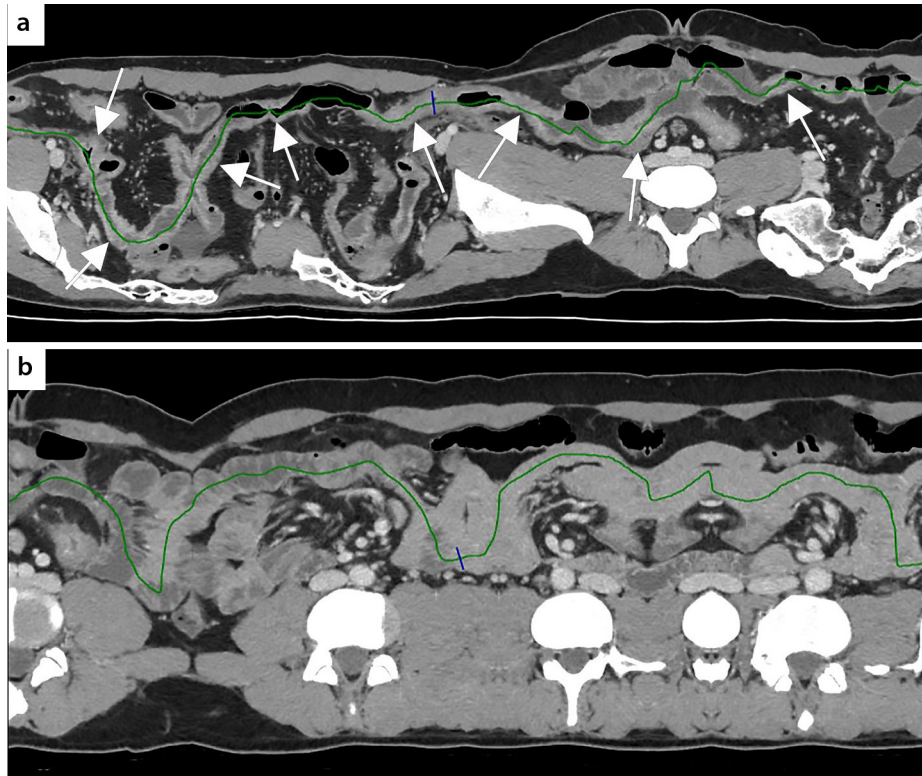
Computed tomography enterography reconstruction (a) reveals extensive alteration of the small loops, both the distal jejunum and ileum, including the last ileal loop and ileocecal valve, for at least 140 cm. The ileocecal valve is poorly identifiable. Immediately upstream, further ileal loops are observed with thickened walls (maximum thickness 10 mm) with an extension of approximately 30 cm and a lumen of reduced caliber (3 mm). The ileum upstream and distal jejunum have at least eight pathological tracts with thickened walls (maximum thickness 7 mm), with a longitudinal extension varying from 2 to 6 cm, and reduced caliber (residual lumen of 4 mm), alternating with tracts of normal or slightly increased caliber (maximum caliber: 25 mm). These alterations are also associated with hypervascularization, increased density of adipose tissue, and reactive lymph nodes in the mesentery. (b) At the request of the surgeon, the healthy intestine was measured and was approximately 70 cm.
